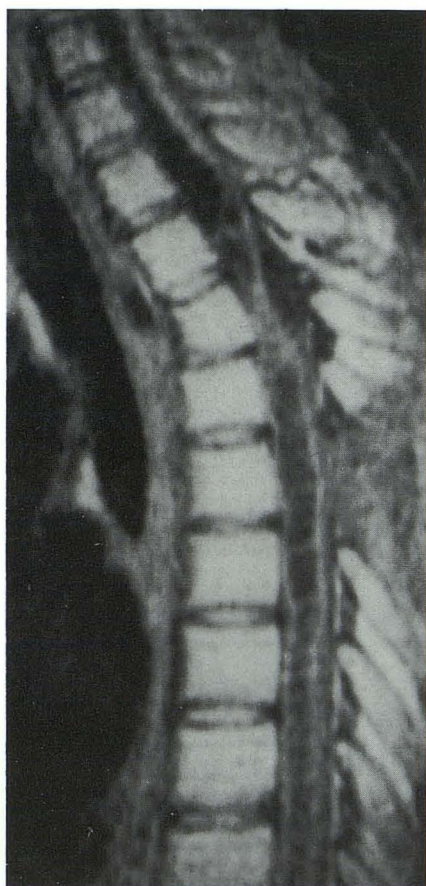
Thoracic syrinx. Sagittal MR image (SE 600/15) on a 28-year-old man whose Frankel grade increased from C to A 10 months following a motor vehicle accident. A large syrinx extends caudally from the original site of injury at T3-T4, and a smaller, septated syrinx extends cranially. The spinal cord is adherent to the theca posteriorly. The findings were confirmed at surgery, and the patient improved to grade B following drainage of both syrinxes.
